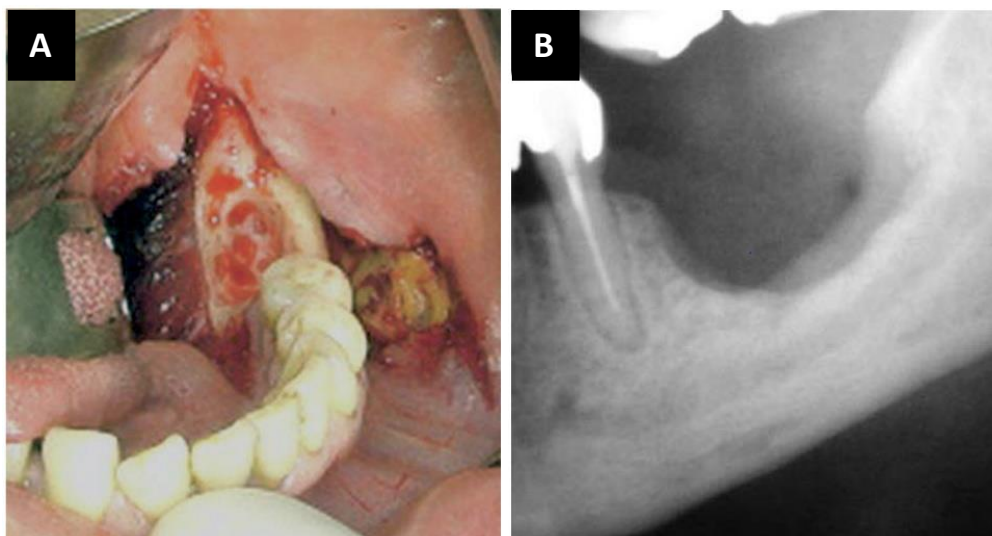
Appearance of necrotic bone and the surgical treatment. (A) Marginal resection of the necrotic bone in the mandible. (B) Radiograph of the mandible after bone resection [1].
